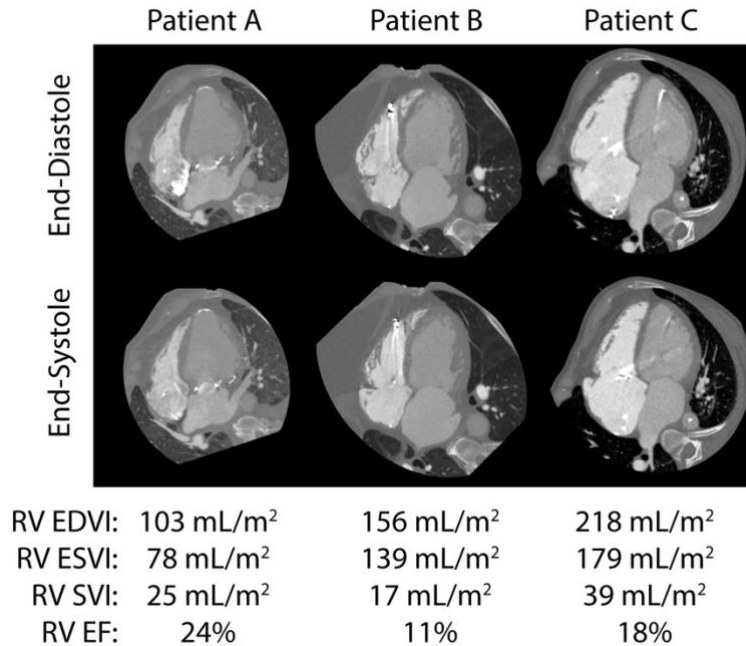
Four-chamber images of three patients who underwent CT-based evaluation of RV size and function prior to LVAD implantation. All have mild RV enlargement and reduced RV function on echocardiographic assessment. Patient A did not experience post-operative RVF while patients B and C required prolonged inotropic support.
